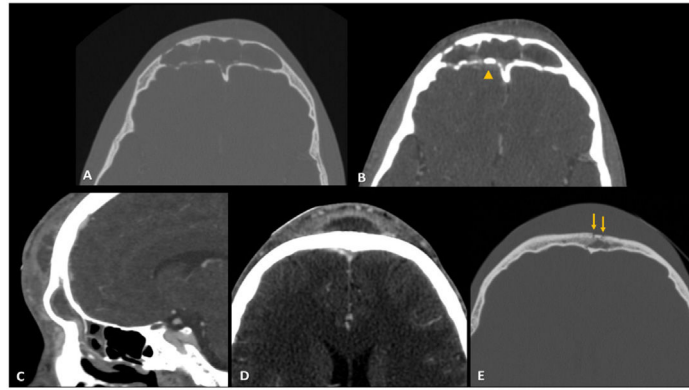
Frontal bone osteomyelitis: Axial ceCT, bone window (A) soft-tissue window (B), show frontal sinus opacification and cortical erosion of the posterior wall of the frontal bone, in keeping with osteomyelitis. Posteriorly to the cortical bone erosions, there is linear hyperenhancement (arrowhead), without obvious fluid collections, suggestive of focal meningitis. Sagittal (C) and axial (D and E) ce-CT, soft-tissue window (C and D) bone window (E) of another patient, show frontal sinus opacification associated with frontal tumefaction corresponding to a subperiosteal abscess (Pott's puffy tumor). Bone window allows easy identification of cortical erosions in the anterior wall of the frontal bone, in keeping with osteomyelitis (arrows).
